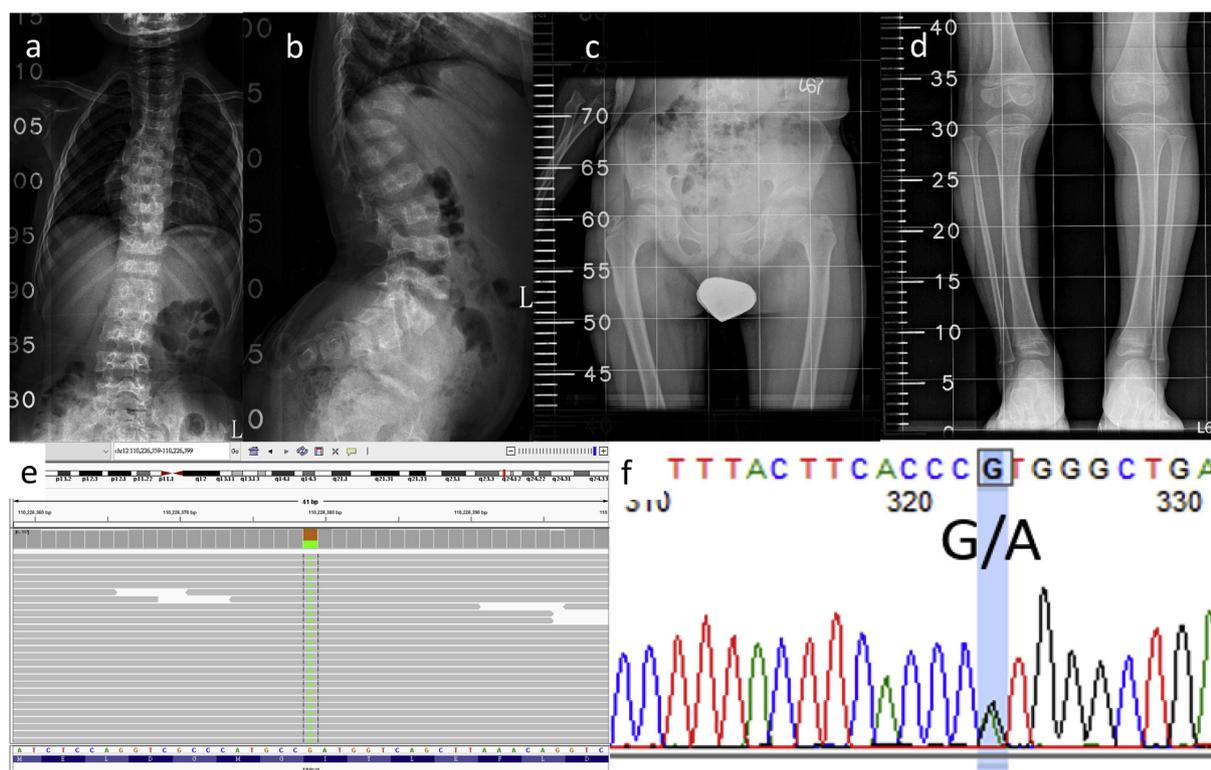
Radiological and molecular evaluation of the patient. Whole spine (a) PA and (b) lateral views depicting flattened vertebra, especially at the T-spine; increased spinal kyphosis at the junction of the T-L spine; widened ribs; and squared bilateral iliac wings. Plain films of the lower extremities (c) and (d) revealing osteopenia, horizontal acetabular roofs and irregular capital femoral epiphyses on both sides, metaphyseal flaring, and bowing deformity of the bilateral tibial shafts. Integrative Genomics Viewer (IGV) screen shot of the *TRPV4* gene depicting the c.1781G > A (p.Arg594His) mutation (e), as further confirmed by Sanger sequencing (f).
